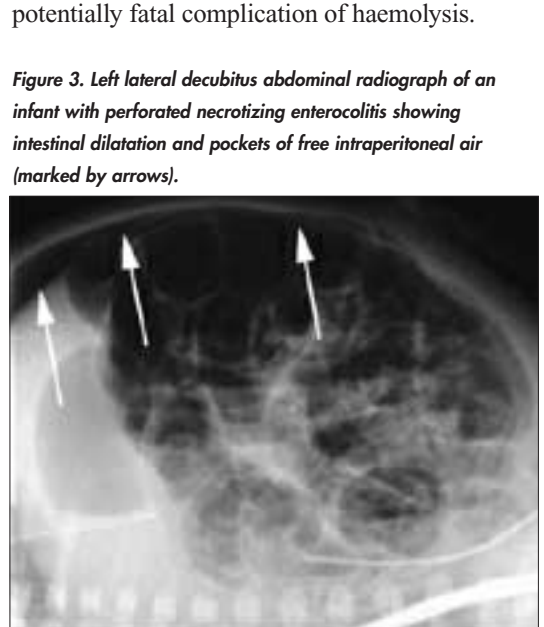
Left lateral decubitus abdominal radiograph of an infant with perforated necrotizing enterocolitis showing intestinal dilatation and pockets of free intraperitoneal air (marked by arrows).
